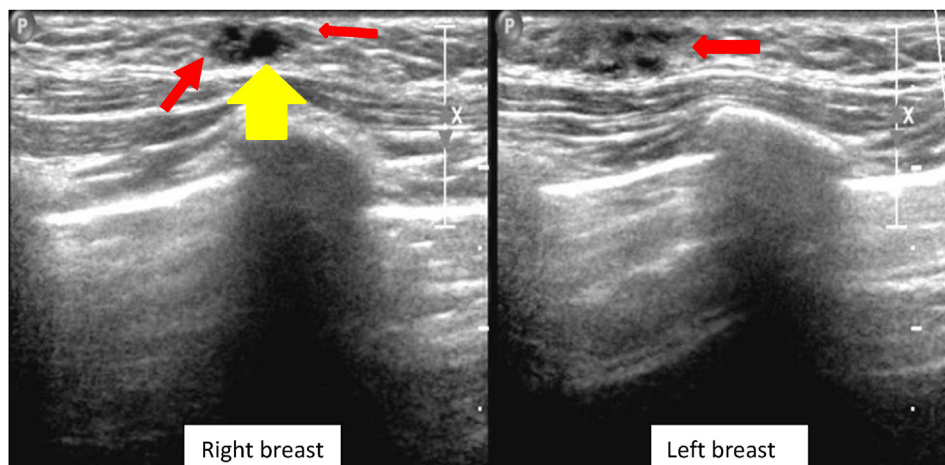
Ultrasound of the breast: there are small bilateral retro-areolar glandular tissues (thin arrows). There is mild dilatation of the right retroareolar ducts (thick arrow), when compared to the left side.
